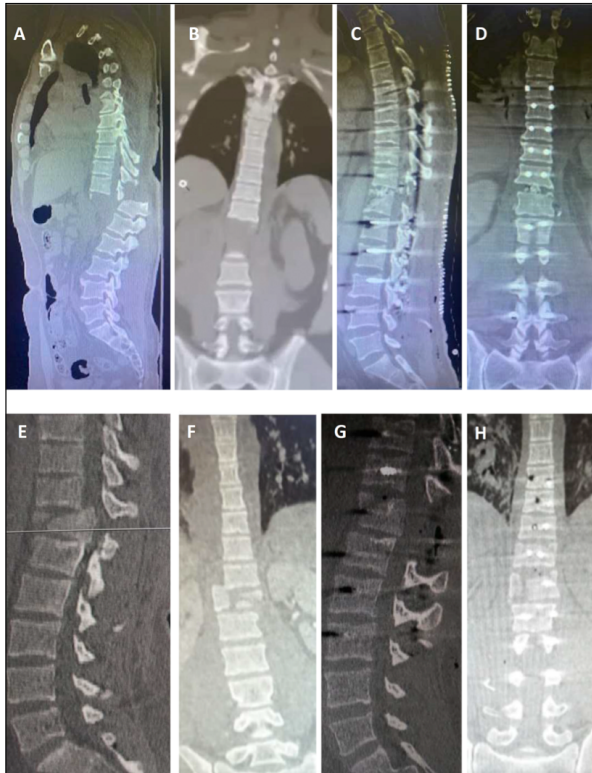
(a) Preoperative sagittal thoracolumbar CT image of Case 5, (b) Preoperative coronal thoracolumbar CT image of Case 5, (c) Postoperative sagittal thoracolumbar CT image of Case 5, (d) Postoperative coronal thoracolumbar CT image of Case 5, (e) Preoperative sagittal thoracolumbar CT image of Case 6, (f) Preoperative coronal thoracolumbar CT image of Case 6, (g) Postoperative sagittal thoracolumbar CT image of Case 6, (h) Postoperative coronal thoracolumbar CT image of Case 6.
